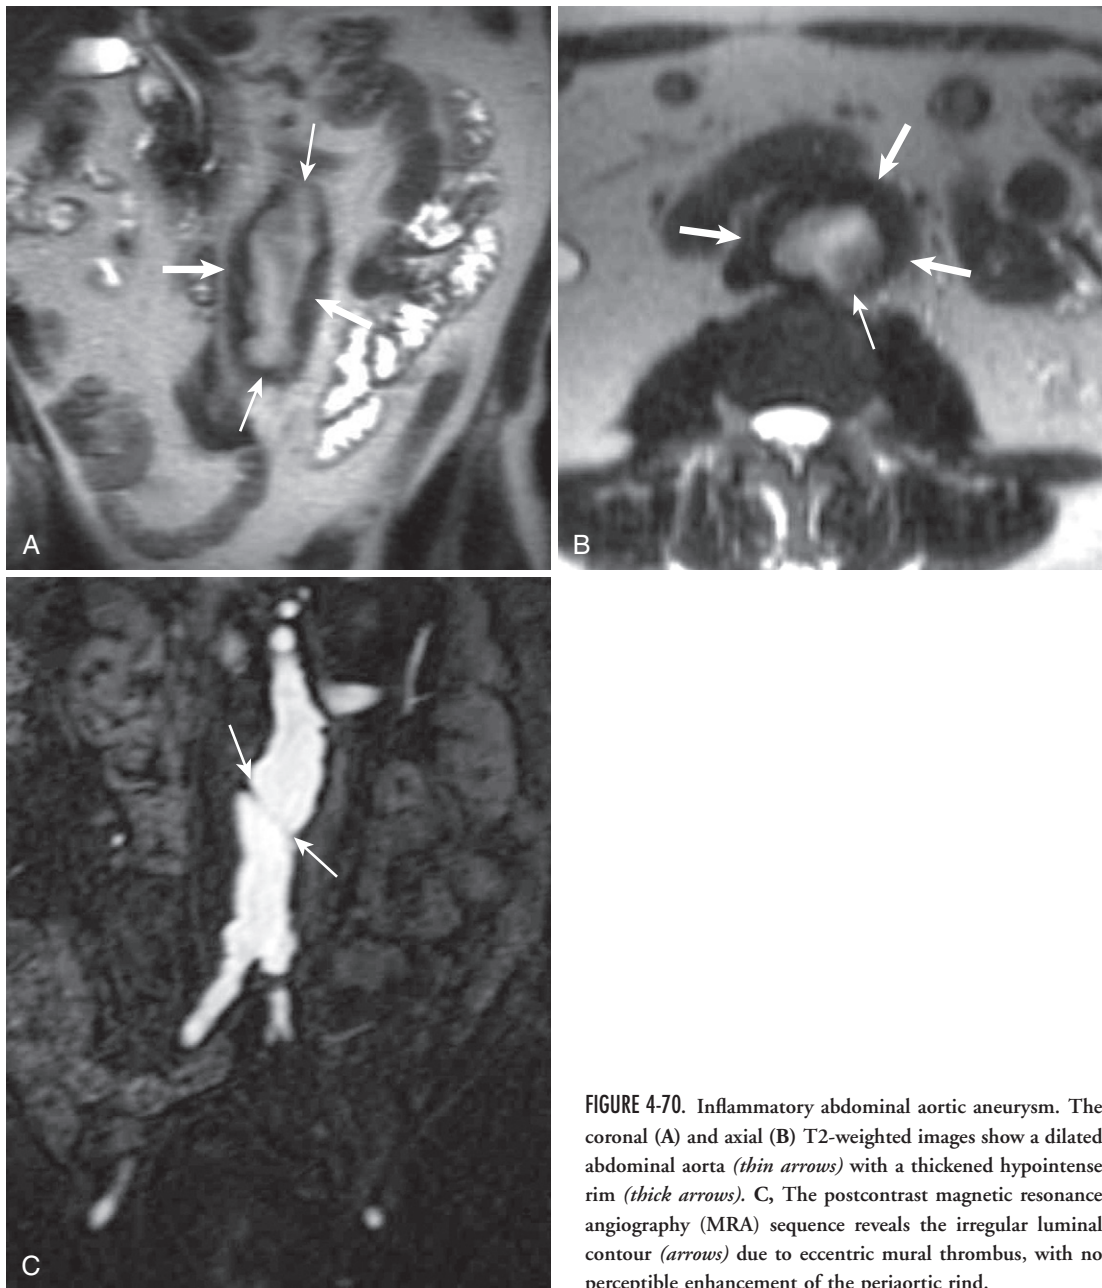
Inflammatory abdominal aortic aneurysm. The coronal (A) and axial (B) T2-weighted images show a dilated abdominal aorta (*thin arrows*) with a thickened hypointense rim (*thick arrows*). C, The postcontrast magnetic resonance angiography (MRA) sequence reveals the irregular luminal contour (*arrows*) due to eccentric mural thrombus, with no perceptible enhancement of the periaortic rind.
